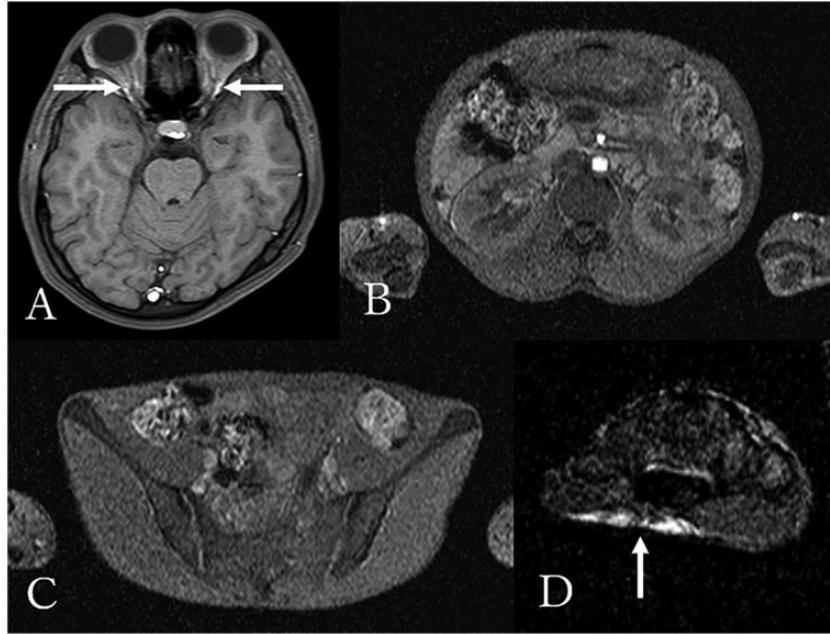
Whole-body MRI performed 10 years ago. (a) Orbital, (b) renal hilar, (c) pelvic level, and (d) left hand on axial T1-weighted image shows an almost total lack of fat tissue, while a small amount of fat was preserved in the palm and retro-orbital space (arrows).
